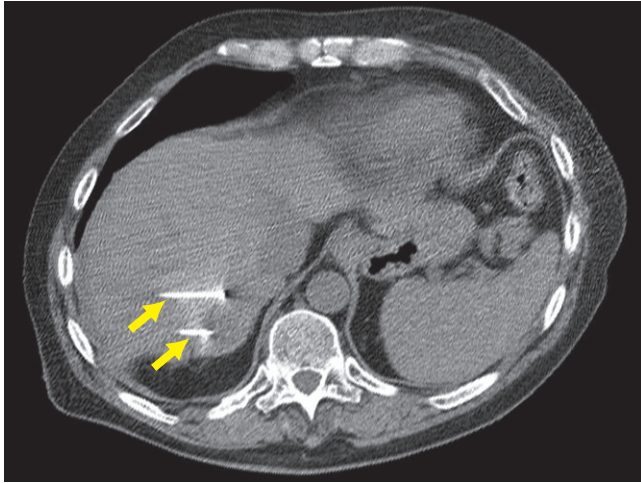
CT scan performed showing radiofrequency electrodes (arrows) during ablation.
